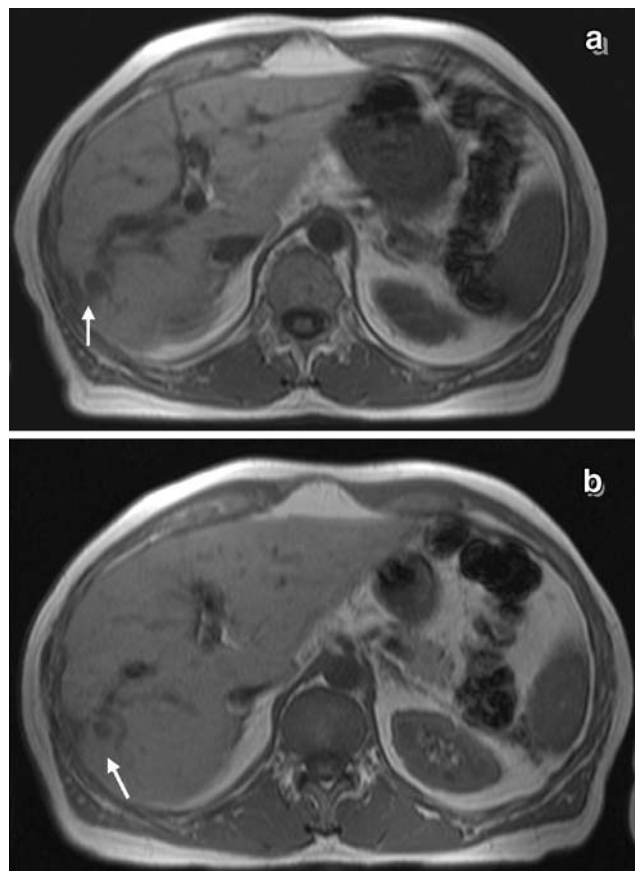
a, b A situation of stable disease achieved after 20 months of regional chemotherapy in a 50-year-old patient (CRC: T2, N1, M1) including three sessions of TACE, followed by three sessions of chemoperfusion. a Pre-treatment non-contrast axial T1-weighted MRI showing a small right lobe lesion (*arrow*). b Follow-up MRI after 20 months using the same imaging technique showing notable size reduction of the tumour (*arrow*). No newly developed lesions were detected
